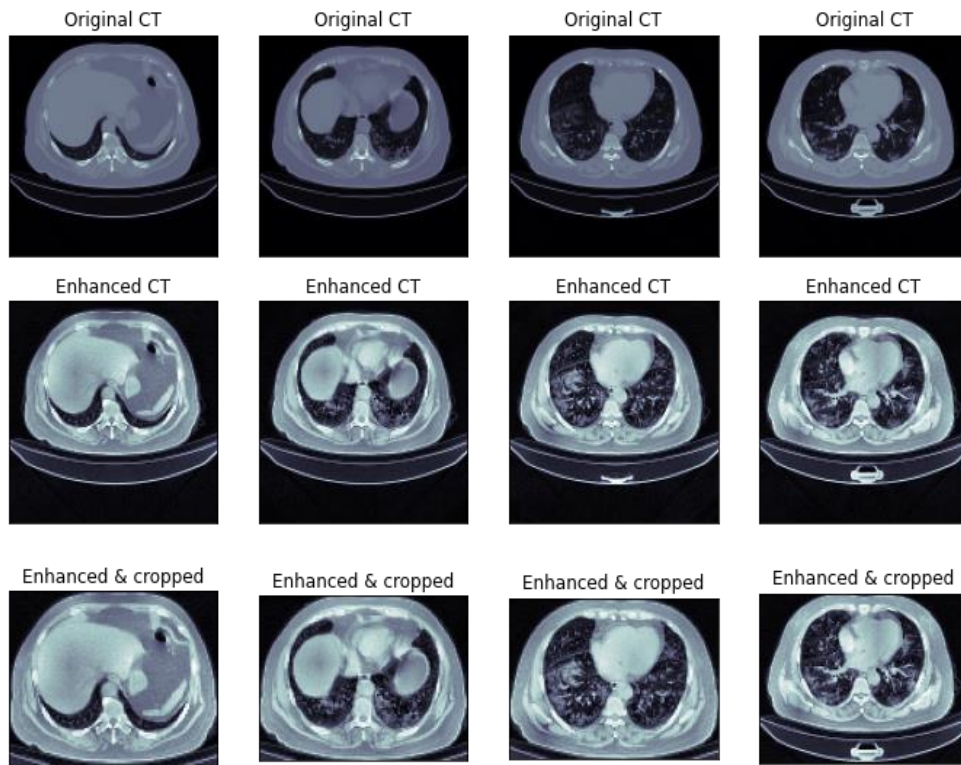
visualization of CT scans of COVID-19 after applying CLAHE and ROI cropping
